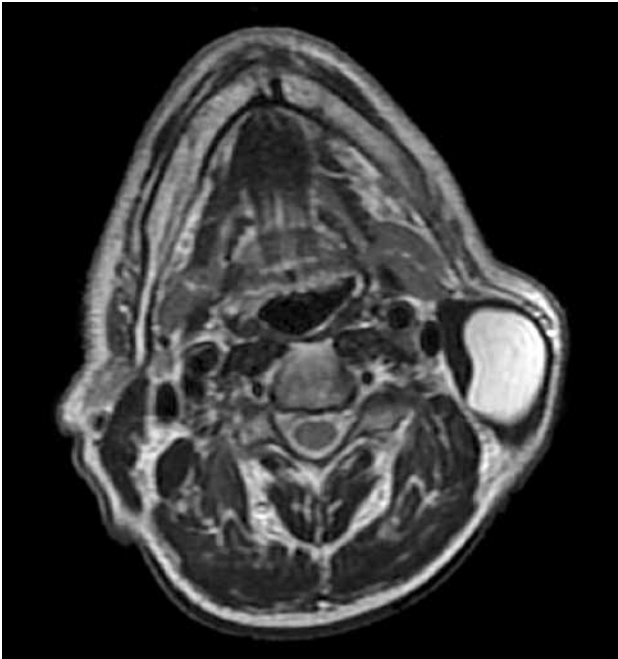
Axial fat-suppressed T₂-weighted magnetic resonance imaging demonstrated a high density mass in the sternocleidomastoid muscle.
